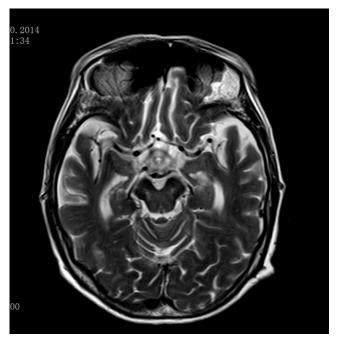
T2 image of first MRI scan presenting intensity changes at temporomesial and limbic areas
